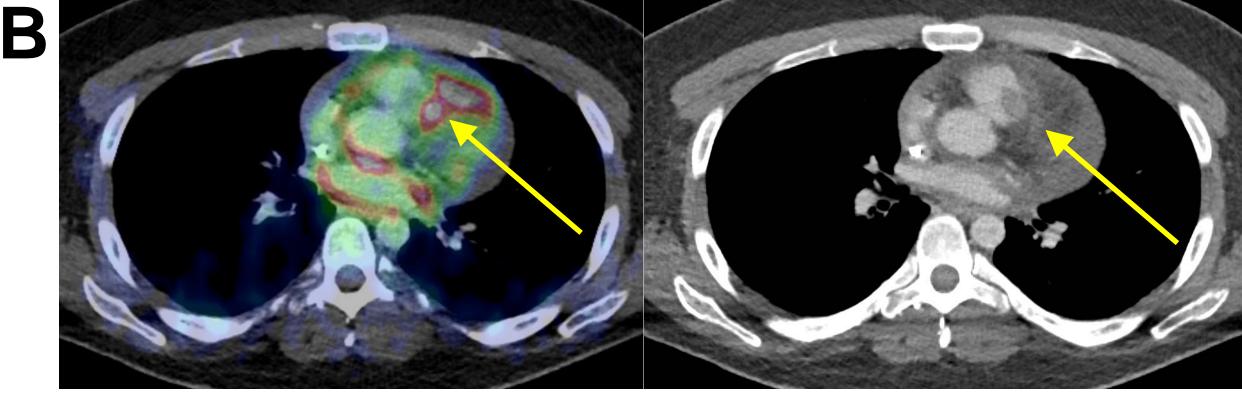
Fused 18F-FDG PET/CT (left) and CT (right) images demonstrate an hypermetabolic lesion in the thickened septum (arrows).
